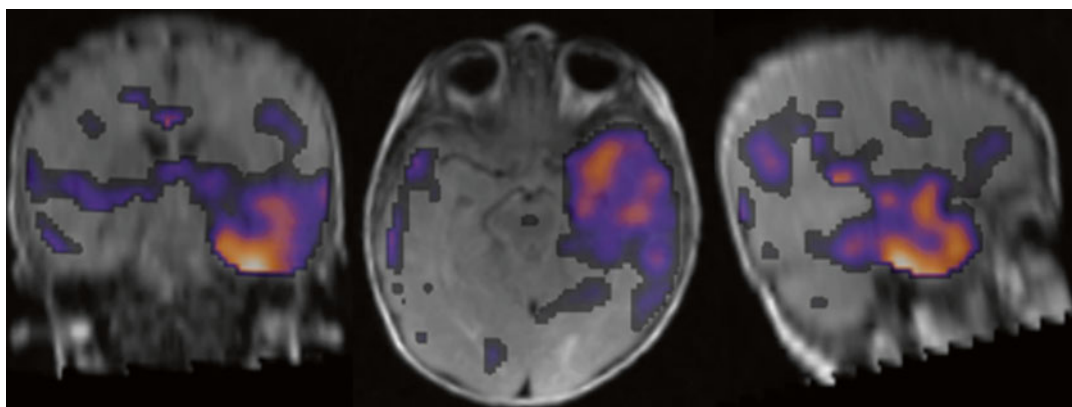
$^{99\text{m}}\text{Tc}$ -ECD perfusion brain SPECT. Ictal minus interictal perfusion SPECT has been subtracted and fused to an MRI. There is differential ictal increase of cerebral blood flow in the left temporal lobe
